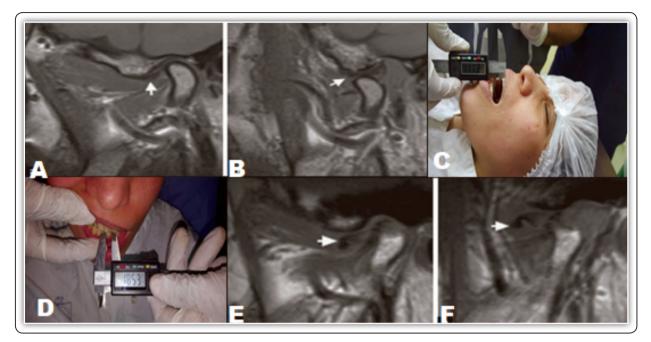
A; T1-Weighted sagittal magnetic resonance images of one case in closed, B; open-mouth positions showing anterior disc displacement with reduction, C; preoperative maximum mouth opening measurements, D; preoperative left and right lateral excursive movement's measurements, E; T1-Weighted sagittal magnetic resonance images of another case in closed, F; open-mouth positions showing anterior disc displacement without reduction
